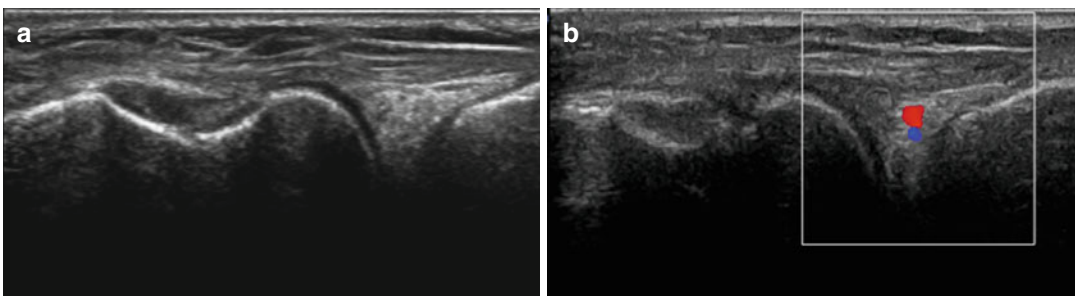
(a) Anterolateral meniscus (b) Vascular Doppler technology
